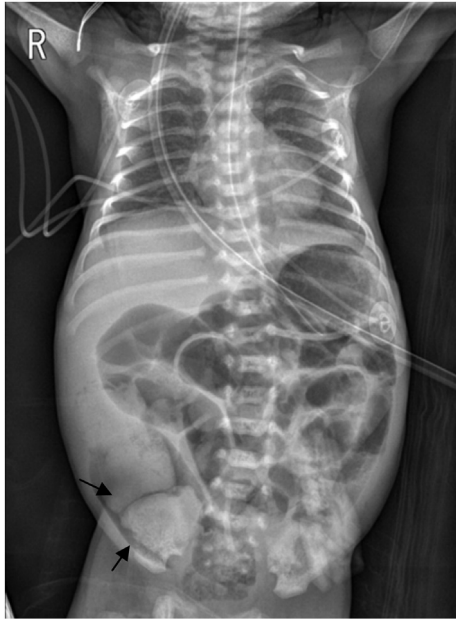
Abdominal radiograph on post-natal day 11, showing bowel dilation and a radioopaque mass-like lesion in the RLQ (arrow).
